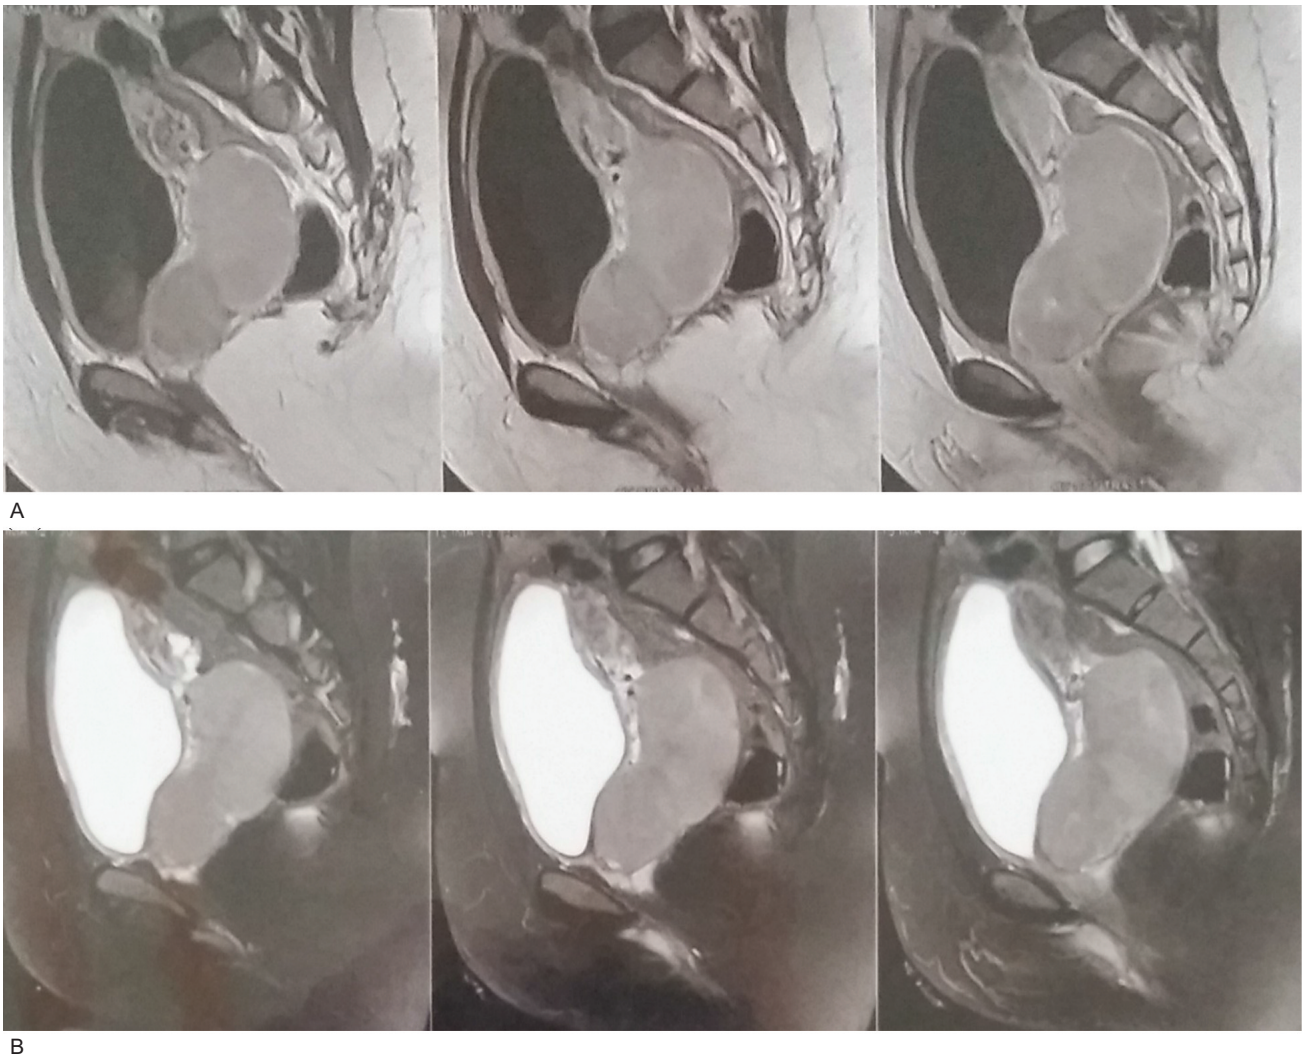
Magnetic resonance imaging revealed a large homogenous well-defined cervical solid mass with (A) low signal on T1-weighted (W1) and (B) high signal on T2-W.
